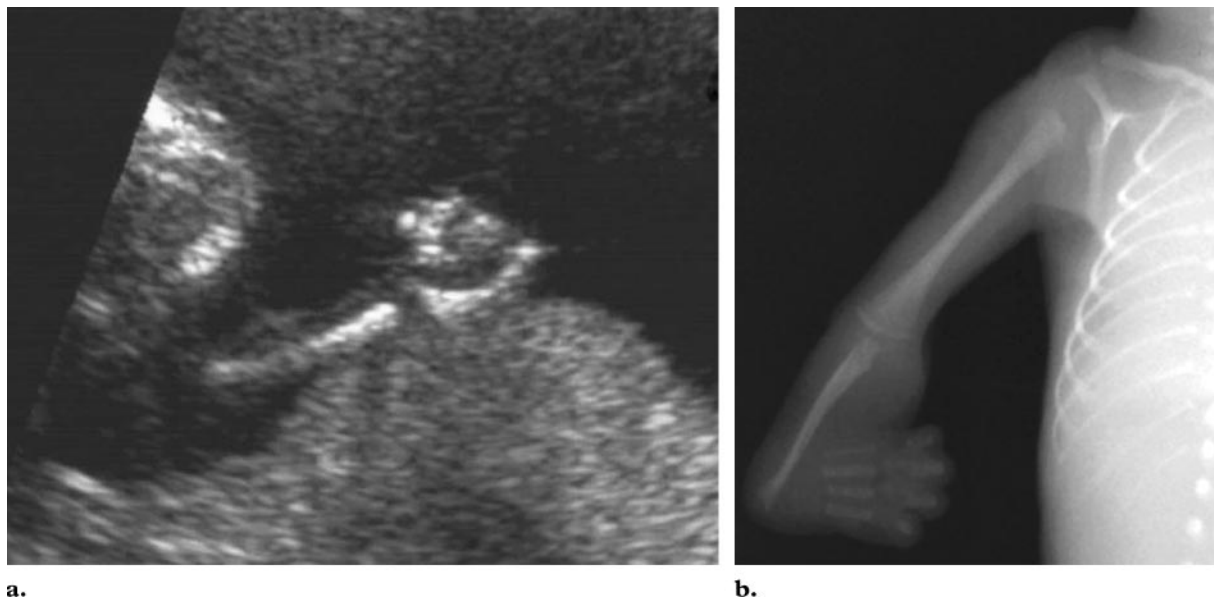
Diffuse akinesia. (a) US image in a fetus at 23 weeks of gestation shows the left wrist flexed, the hand closed, and the elbow extended, a position that remained unchanged during two successive examinations. (b) Corresponding radiograph of the left upper limb of the same fetus shows a clubhand and a normal radius and ulna. The other three limbs (not shown) also manifested fixed deformities.
